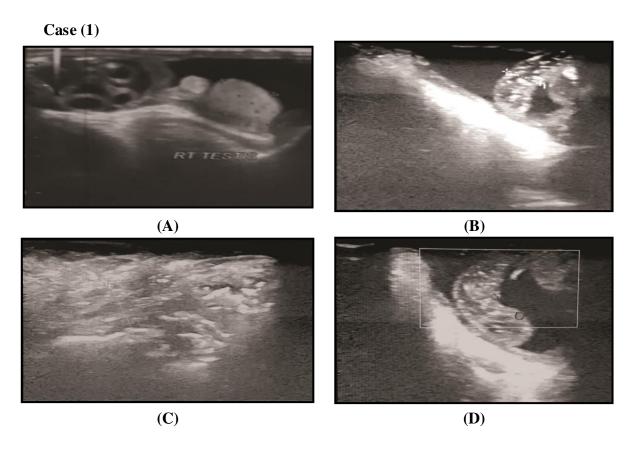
Sonography evaluation of A child 3 months, male patient, presented with irreducible right inguinal hernia. Ultrasound revealed (A)- a day before- us showed reducible hernia not reach scrotum, B, C & D at time of presentation, (B) thick walled bowl loops (3.5 mm), free fluid within the hernia sac, (C) hernia neck measuring 0.89 cm (D) arterial a and venous flow seen within the bowl wall. Diagnosis was incarcerated right inguinal hernia and the patient underwent reduction of viable loops then hernioraphy.
